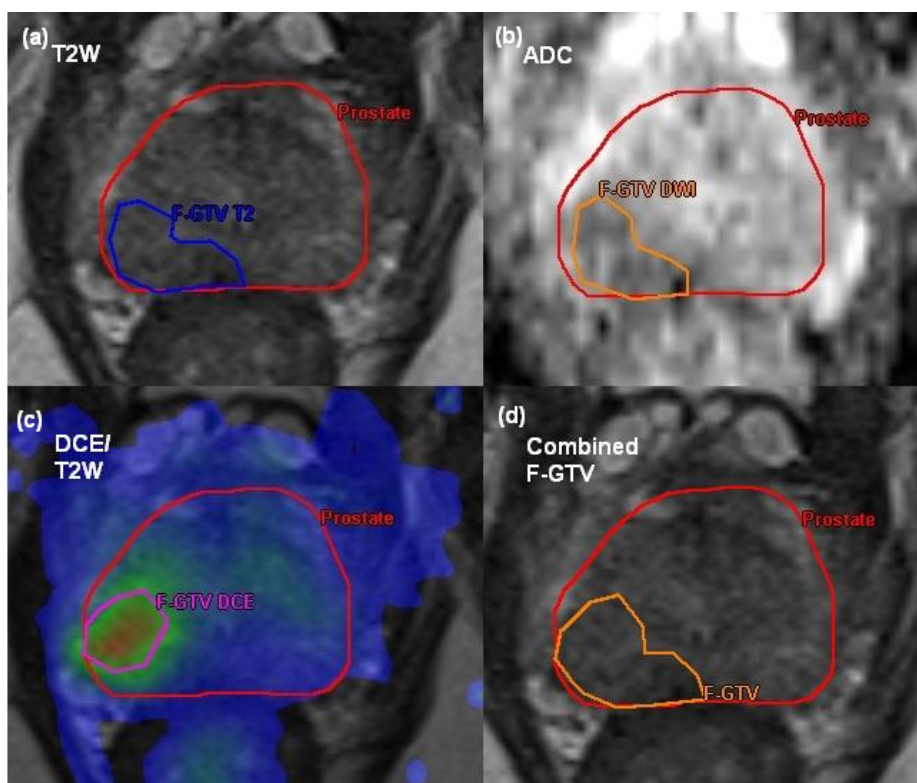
Example of tumour delineation on (a) T2 weighted MRI (b) DWI MRI ADC map (c) DCE-MRI Ktrans map superimposed on T2W MRI. (d) shows the F-GTV derived from (a), (b) and (c)
